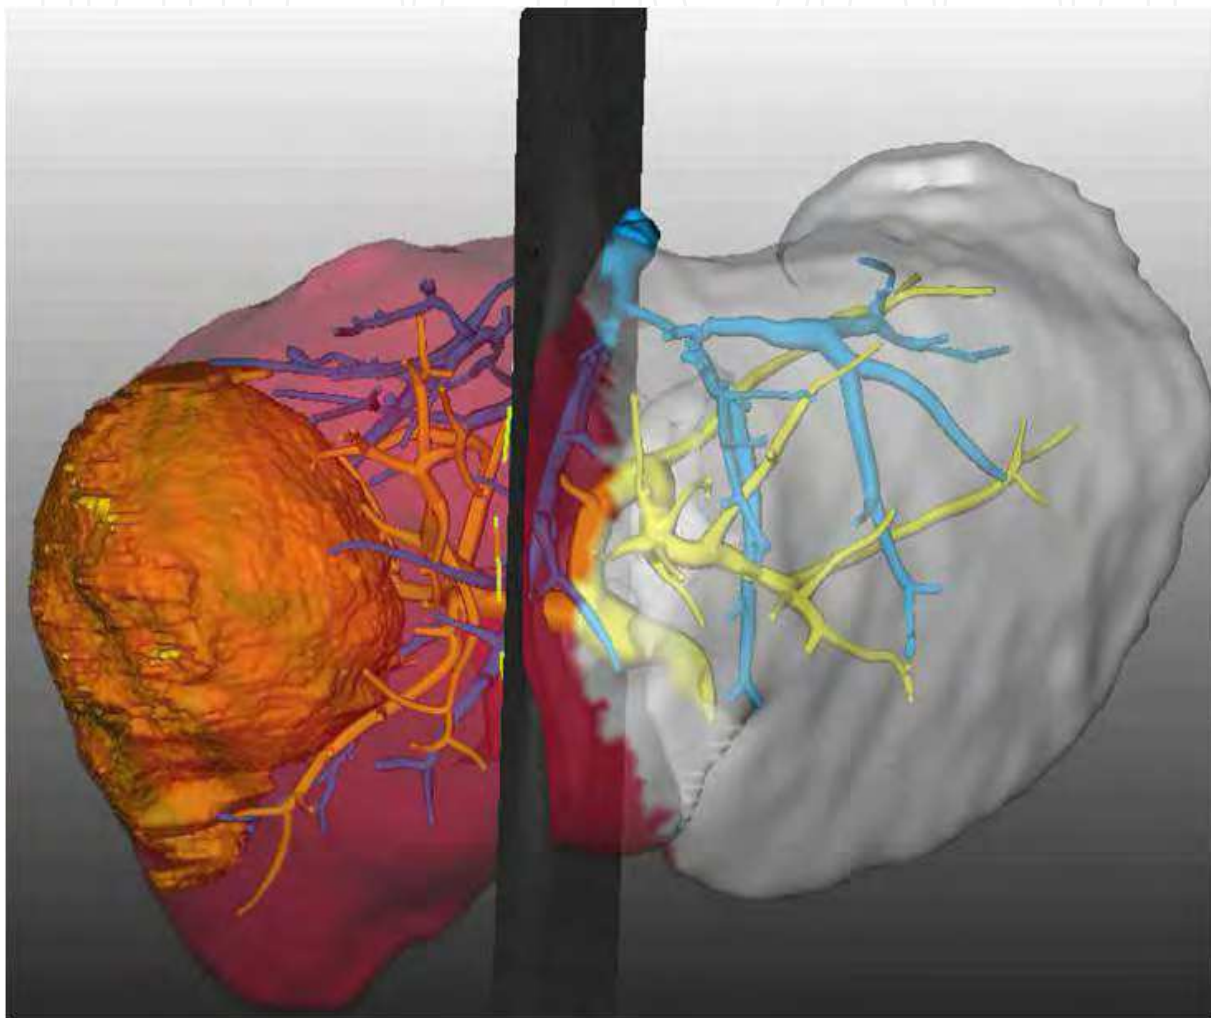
3D modelling of a large right lobe metastatic lesion based on CT data obtained using the MeVis system (HepaVision, Bremen, Germany), that allows visualization of the vasculature of the mass, as well as its relation to the venous drainage system of the liver and an estimation of the remaining liver volume based on the proposed resection plane.
